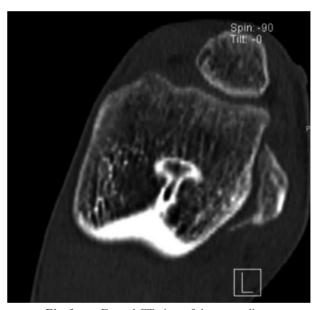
Frontal CT view of the same elbow
